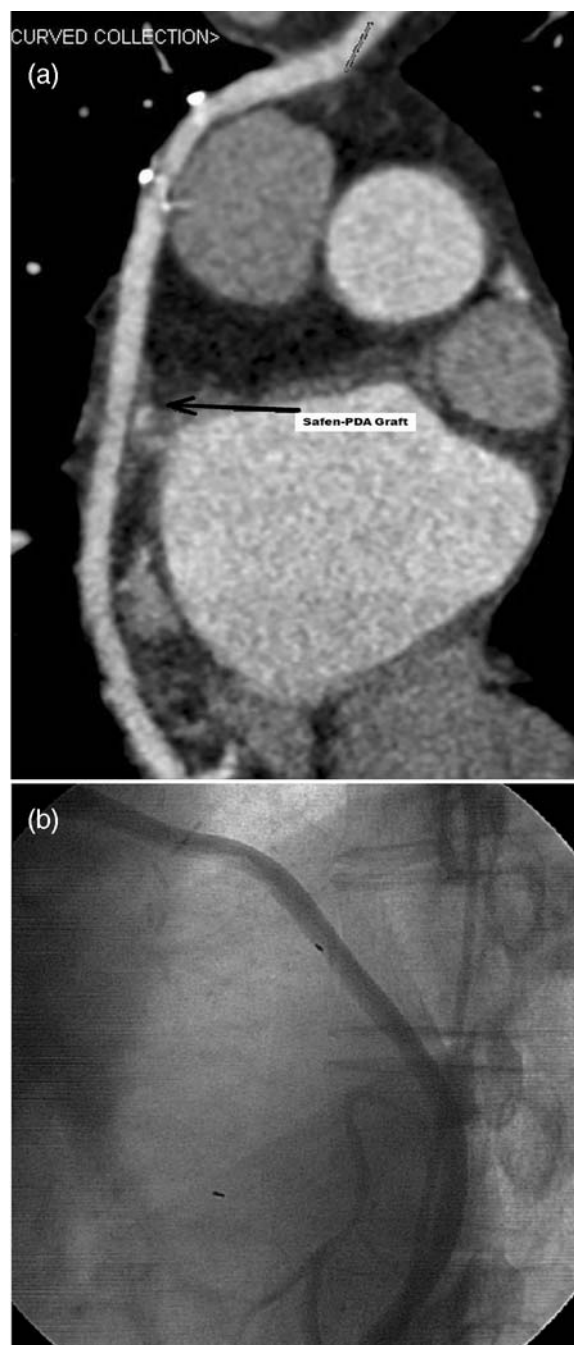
A 48-year old male patient with a history of coronary artery bypass grafting (CABG) 2.5 years ago admitted with atypical chest pain. 16-Slice-computerized tomography (CT) coronary angiography revealed normal safen-posterior descending artery (PDA) graft (a). Owing to significant stenosis in left anterior descending artery (LAD) to left internal mammary artery (LIMA) graft, the patient underwent invasive coronary angiography and showed patent safen-PDA graft (b).
